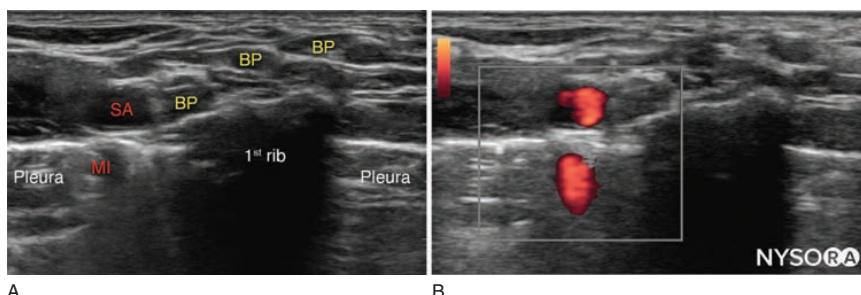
Ultrasound image of the subclavian artery at the supraclavicular level that shows an example of a mirror image (MI) above and below the pleura. BP, brachial plexus; SA, subclavian artery.
